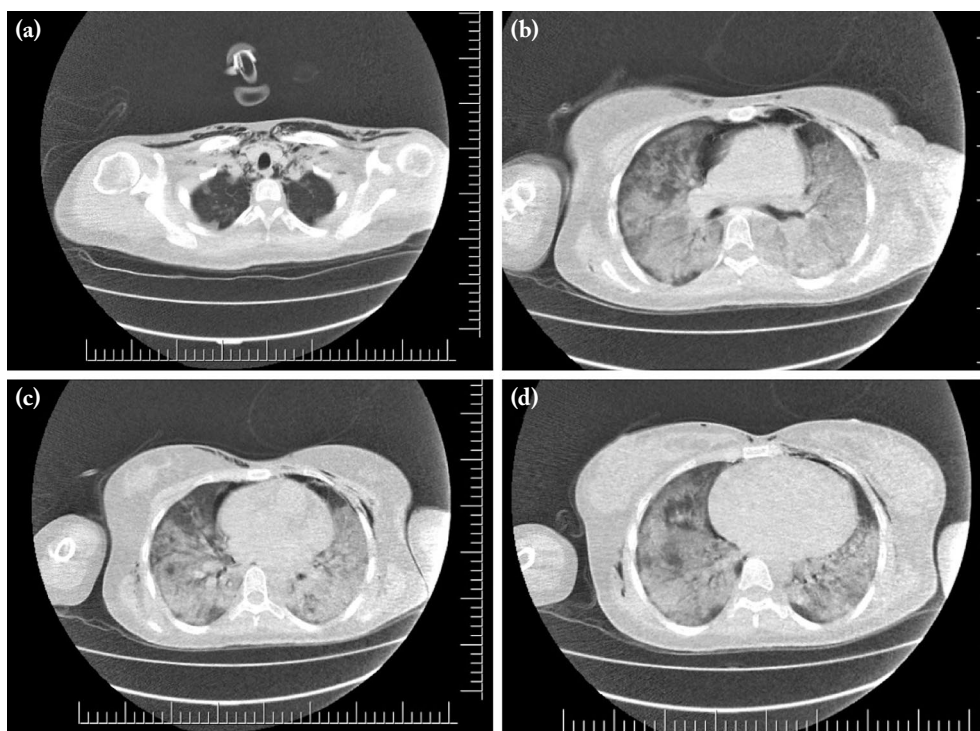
Initial computed tomography scans after cesarean section. (a) Subcutaneous emphysema; (b-d) pneumomediastinum and bilateral ground-glass opacities.
